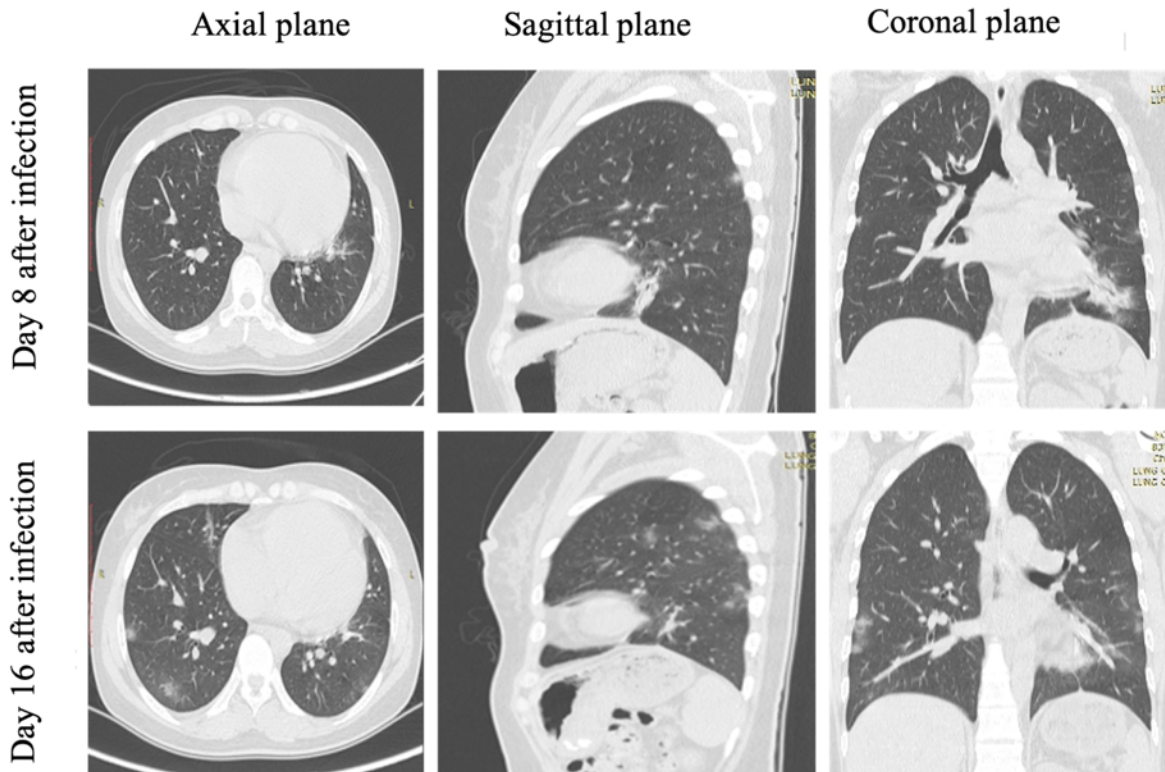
CT scan of case 2. CT scan showed subpleural band with low density and a ground glass opacity in the lower lobe of right lung on day 8. Consolidation was present in the lower lobe of lung. On day 16, size of the ground glass opacity got bigger in both lungs whereas size of the mass in the lower lobe of the lung was broken and decreased.
